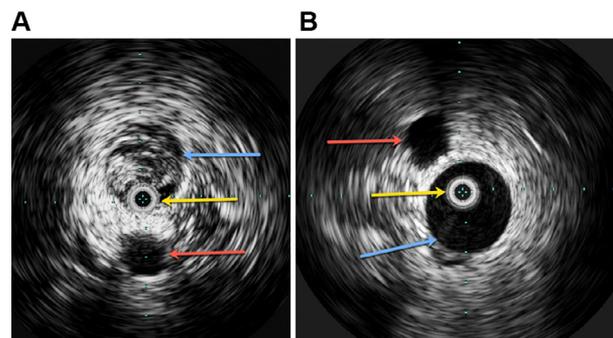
A 16-year-old female presented with thrombosed right lower extremity deep venous system extending from popliteal vein to the right common iliac vein. (A) Intravascular ultrasound (IVUS) of the right common iliac vein shows the vessel lumen filled with echogenic material representing occlusive clot (blue, solid arrow), the IVUS transducer within the lumen of the vessel (yellow, solid arrow), and the right iliac artery (red, solid arrow). (B) After 24 hours of catheter directed thrombolysis (CDT), IVUS demonstrates patency in the right common iliac vein (blue, solid arrow), IVUS transducer (yellow, solid arrow), and the right iliac artery (red, solid arrow). (Color version of figure is available online.)
